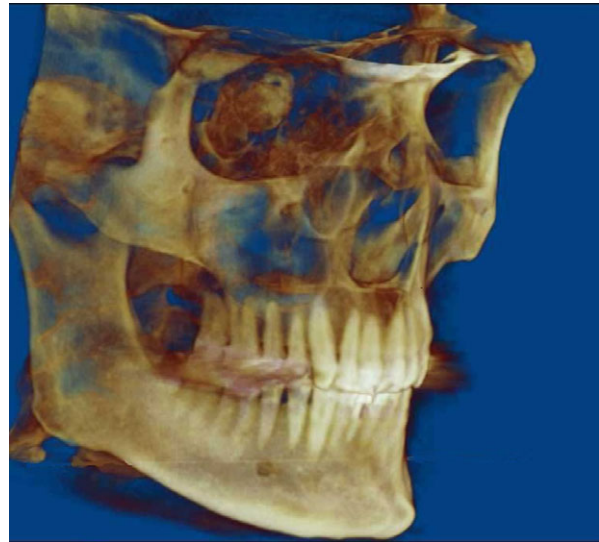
Three-dimensional reconstruction of a cone-beam computed tomography with a large field-of-view (FOV) displaying the eyes, base of the skull (and adjacent cranial cavity) and cervical vertebra, and spinal canal, all of which are outside the maxillofacial complex, the area of competence of the dentally qualified clinician. Although dental professionals with a registerable medical qualification may comment on these extragnathic areas, it is prudent to refer to a medical radiologist who has been trained on head-and-neck radiology. Avoidance of this requirement can be achieved by using an appropriately smaller FOV as set out on Figure 6. (Reprinted with permission from MacDonald;² Figure 5.4).
